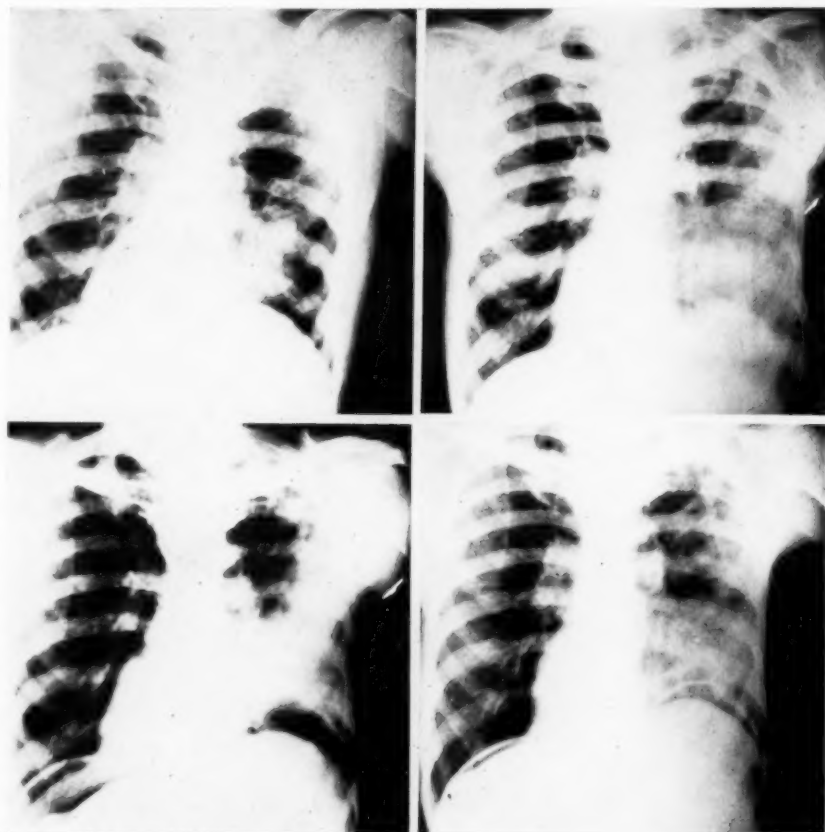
Lung abscess following exposure to cold. Patient was exposed to cold and wet weather for several hours previous to his illness. (a) Radiographic examination made within twenty-four hours revealed a consolidation confined to the hilus region. (b) This rapidly spread towards the periphery until it involved the entire lower portion of the lung. (c) A persistent hiccup and a foul odor to the breath suggested gangrene and subphrenic involvement. Pneumoperitoneum examination revealed the subphrenic space clear. (d) Evacuation of pus through a bronchus was followed by prompt spontaneous cure.
